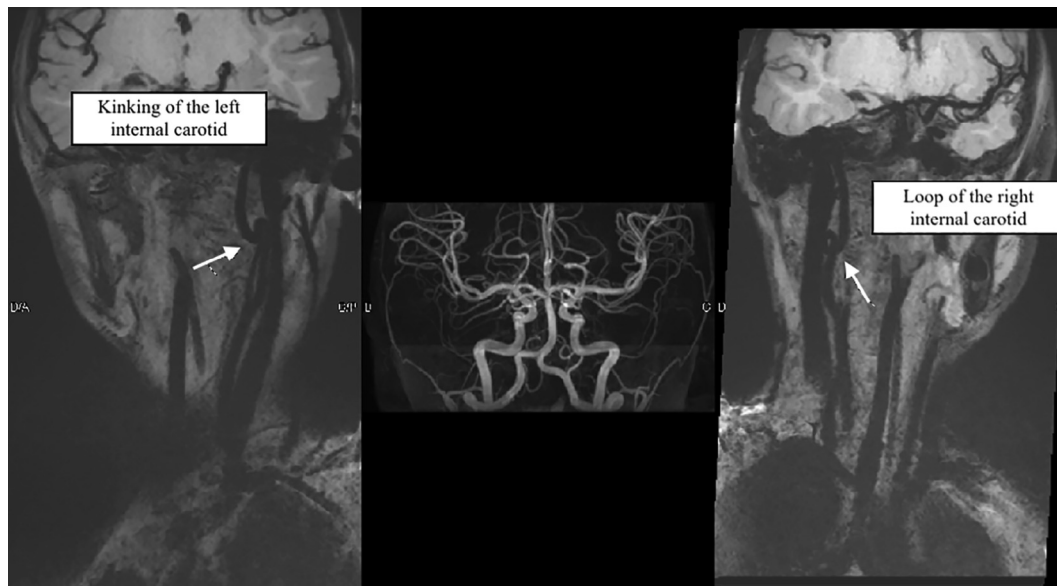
MRI imaging showing a loop of the right internal carotid and a kinking of the left internal carotid.
